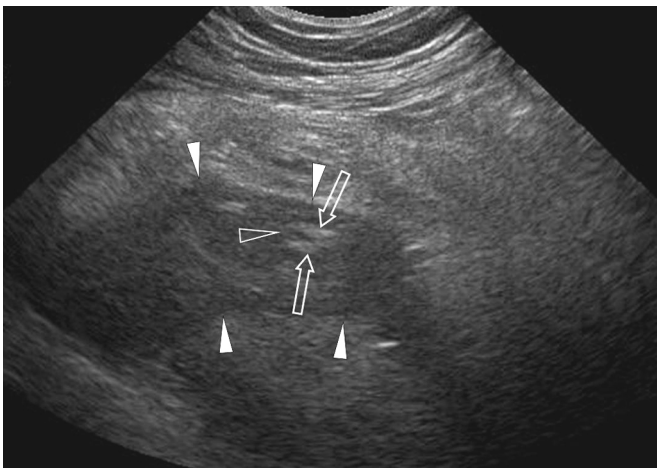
Perforated appendicitis. A. Contrast-enhanced CT scan shows minimal pelvic mesenteric fat content, contributing to the difficulty in detecting the inflamed appendix. B. Contrast-enhanced CT scan obtained at a lower level than (A) shows triangular-shaped fluid collection (arrowheads) in the right side of the pelvic cavity, which suggest periappendiceal abscess as a differential diagnosis. C. In longitudinal ultrasonographic scan, the inflamed appendix (open arrows) with surrounding abscess (arrowheads) is well-visualized.
